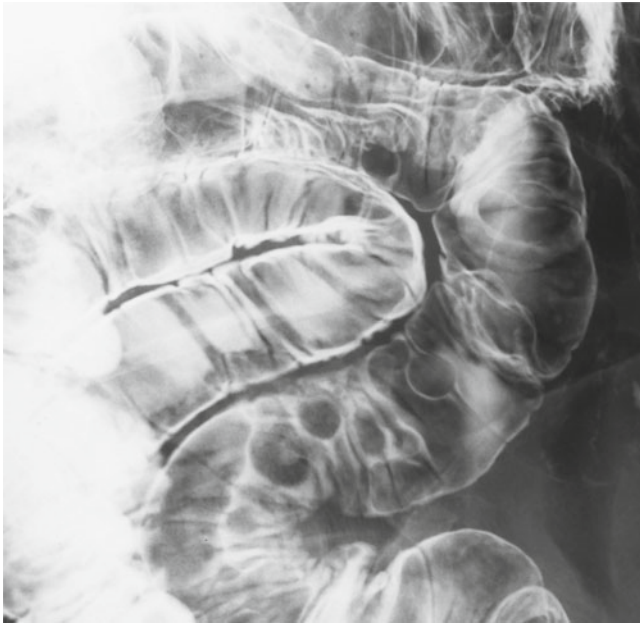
Radiography revealed multiple oval or round filling defects in the central and lower small intestine, some of which displayed barium flecks in the center
